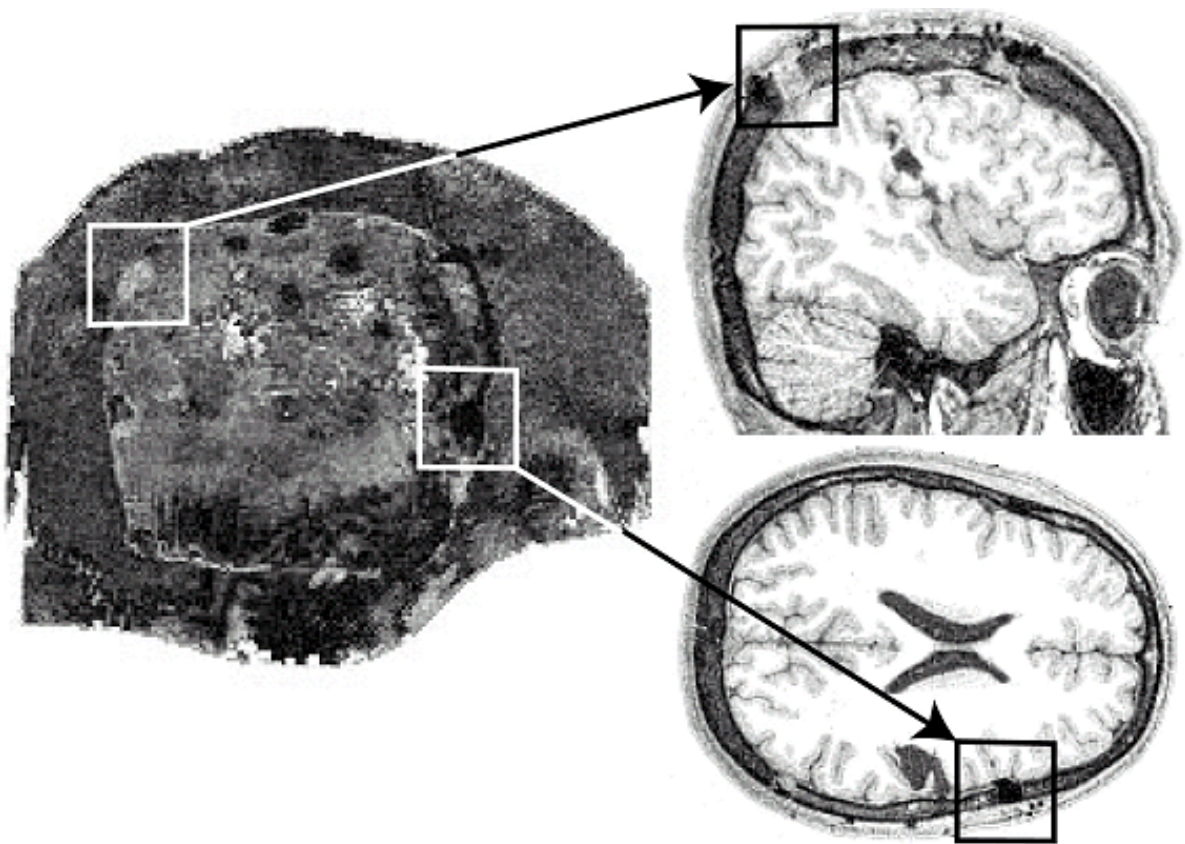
Burr holes as seen with T1-weighted MRI: (left) reconstruction of an image along a curved surface following the skull (Brainsight software); (upper right) open burr hole; (lower right) burr hole that has been filled with methacrylate.
